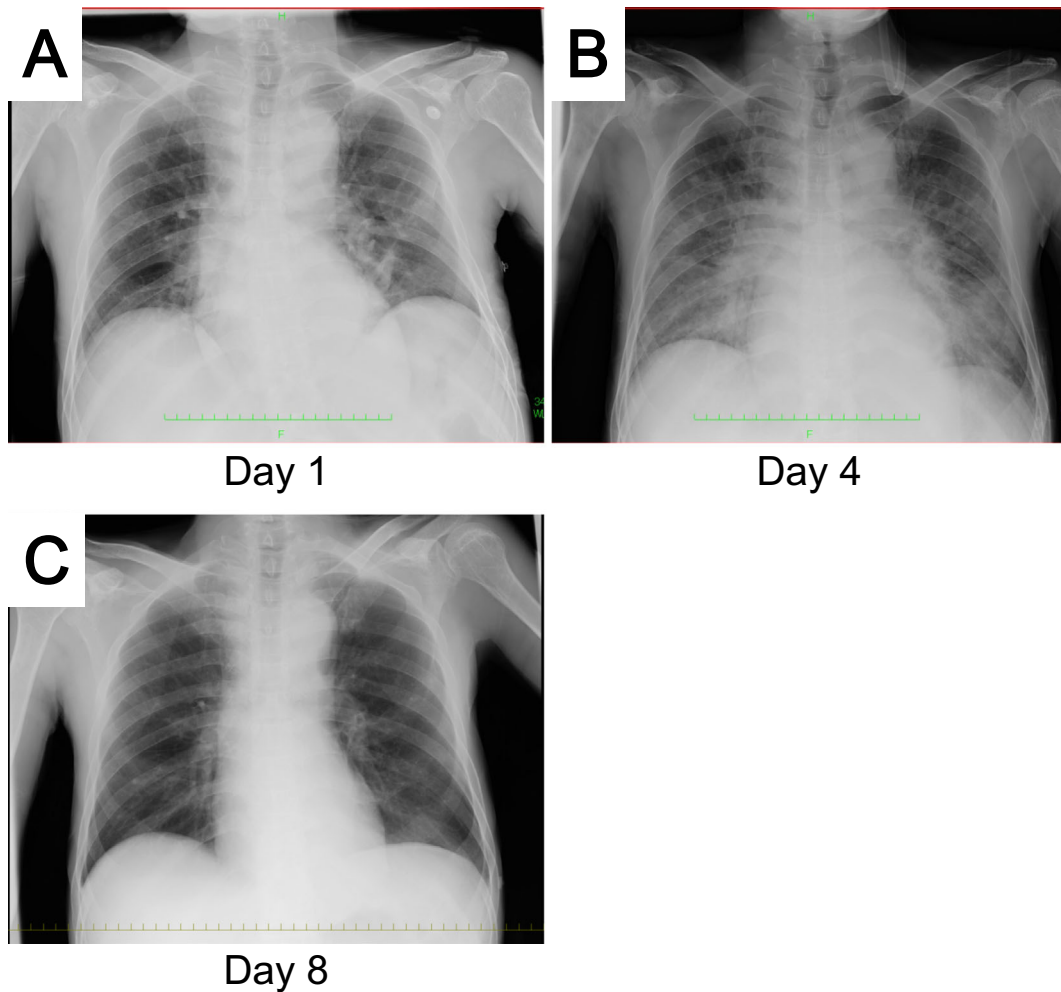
Chest X-ray on the day of admission (A) and days 4 (B) and 8 (C) after admission.
